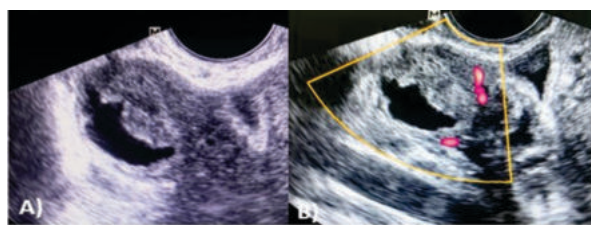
A) Transvaginal Ultrasound Showing Haemorrhagic Ovarian Cyst With Retracted Echogenic Clot (white Arrow). B) Doppler Examination Revealed So Significant Internal Vascularity.
